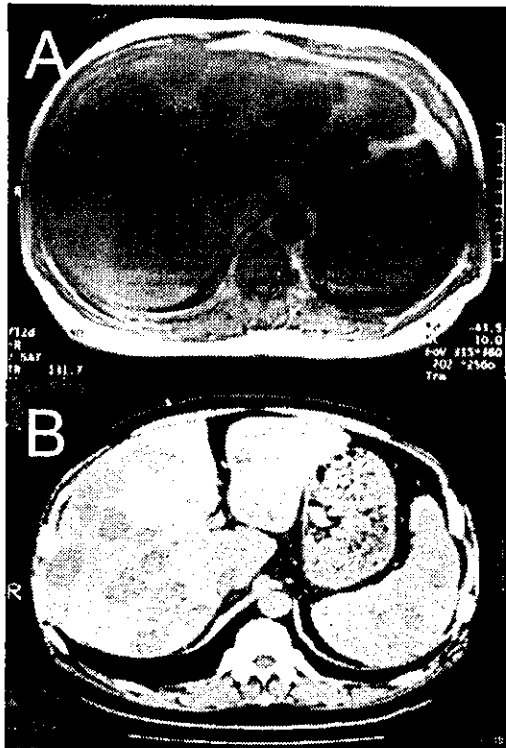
Images of MRI and CT scans. (A) MRI demonstrated multiple nodular lesions in liver and spleen on initial examination. (B) CT scan, 10 days after the CHOP therapy showed the reduction of tumor mass size both in the liver and spleen.
